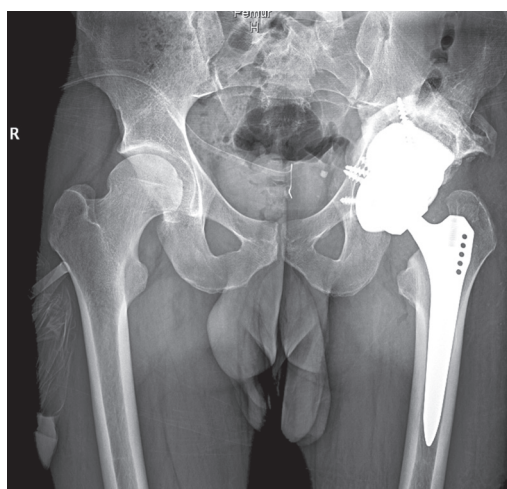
X-ray of the patient: the left hip joint was replaced by an individual endoprosthesis, primary fixation with 7 screws; the position of the components of the endoprosthesis is correct.
